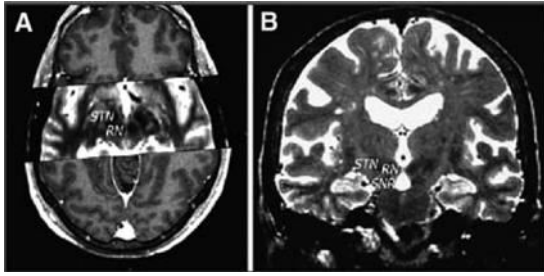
Axial (A) and Coronal (B) T2 weighted MRI scans showing STN (Rezai *et al.* [8])
